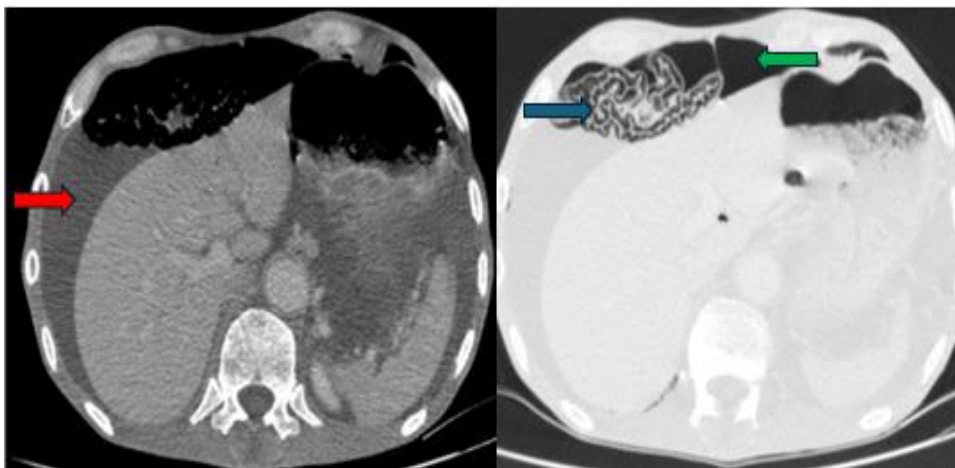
CT scan image demonstrating intestinal pneumatosis cystoides (blue arrow), ascites (red arrow), and pneumoperitoneum (green arrow)
